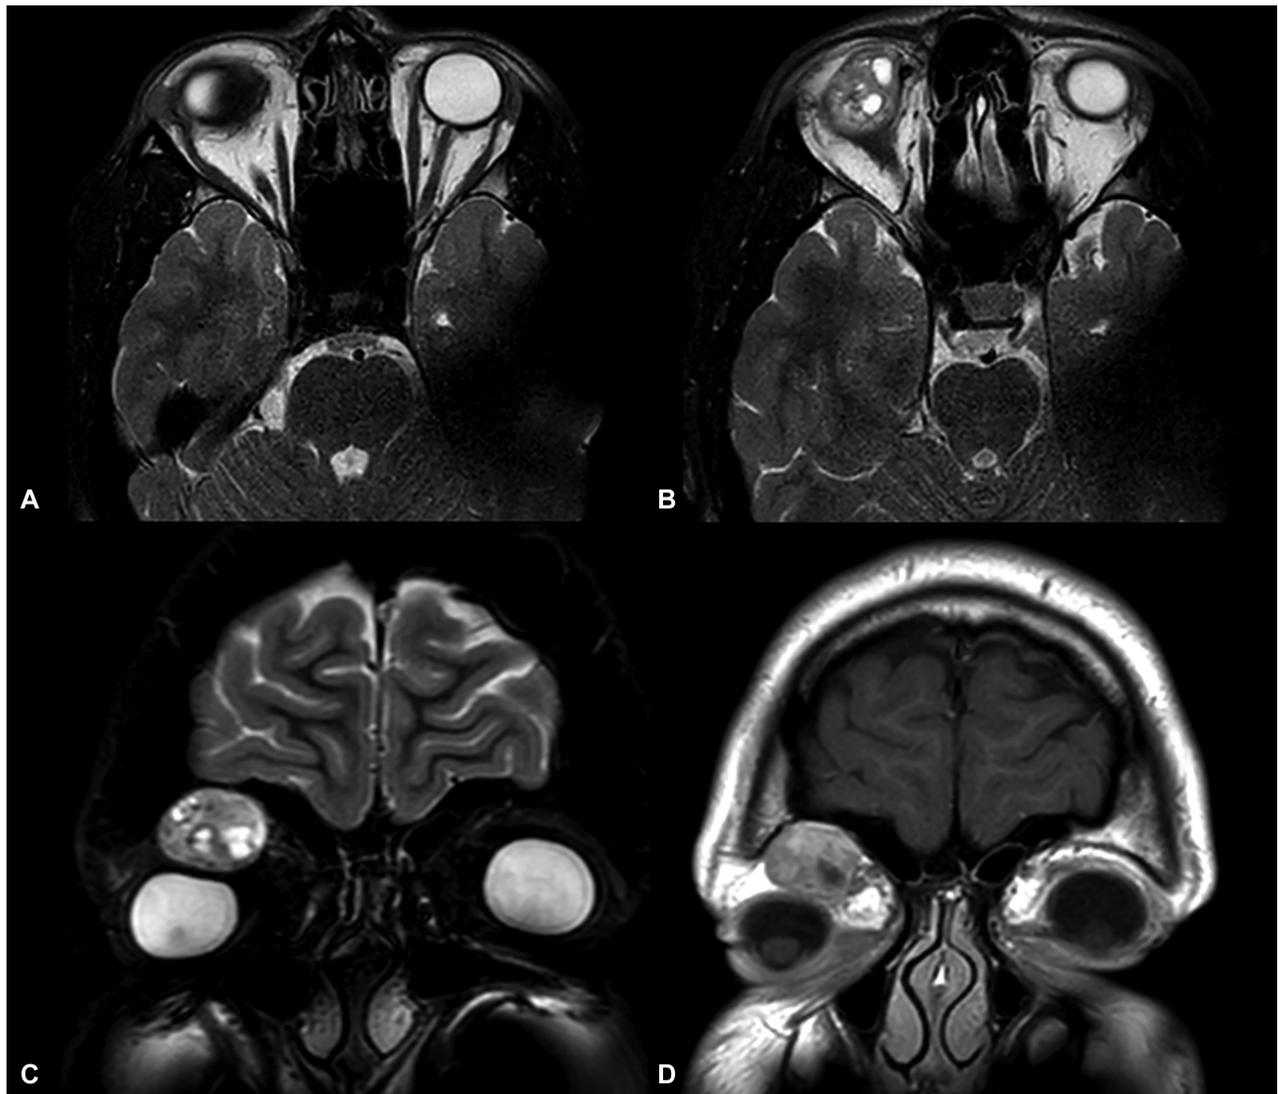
A and B – Magnetic resonance imaging: axial T1 gadolinium sequence showing a right orbit lesion, superior to eye with heterogeneous enhancement. C – Coronal T2 sequence showing the relationship between the tumor and the right eye. D – Coronal T1 sequence that evidences the tumor and its disposition, lateral and superior to the optic nerve.
